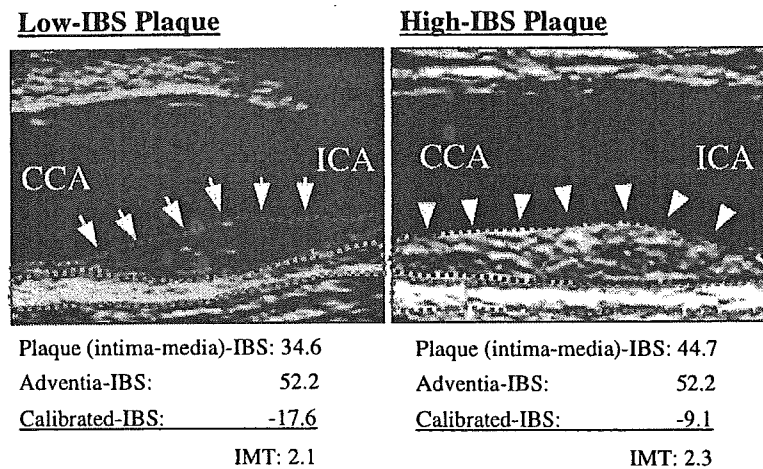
Representative ultrasound images of atherosclerotic carotid plaques with low and high calibrated integrated backscatter (IBS) values. The red dotted line indicates region of interest in the plaque (intima-media complex), and the blue dotted line indicates region of interest in the adventitia using a manual outline definition mode. (Left) Low IBS plaque is identified by arrows. The calibrated IBS value and maximum intima-medial thickness (IMT) of this plaque are -17.6 dB and 2.1 mm, respectively. (Right) High IBS plaque is identified by arrowheads. The calibrated IBS value and maximum IMT of this plaque are -9.1 dB and 2.3 mm, respectively. CCA = common carotid artery; ICA = internal carotid artery.
